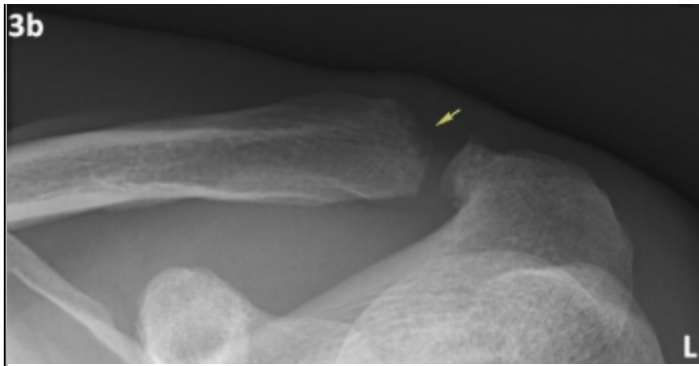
Follow-up radiograph of both AC joints
